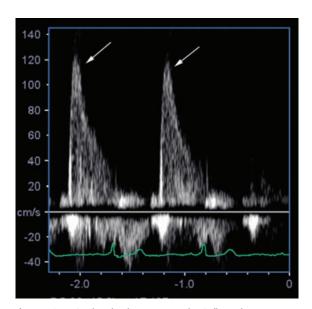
Mitral pulsed-wave Doppler inflow demonstrates an early diastolic E-wave (arrows), but no late diastolic A-wave.
